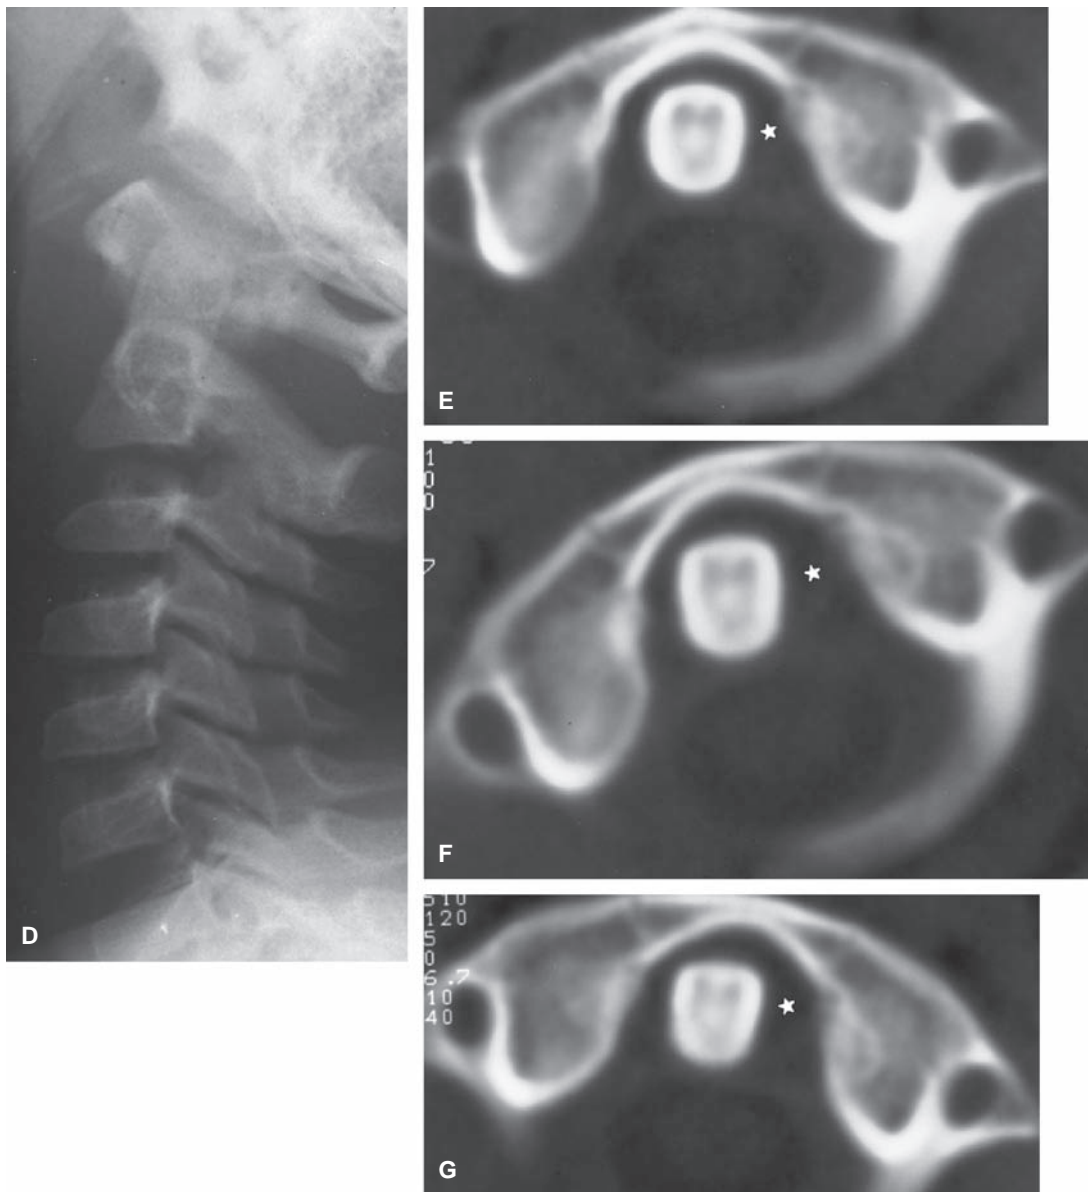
(Continued) D–G: CT evidence of fixed rotary subluxation in a 6-year-old child. D: Lateral radiograph demonstrating mild increased distance of prevertebral space. E: Axial CT scan demonstrating increased distance between dens and patient’s left side of C1 (asymmetry between right and left sides). F: Axial CT scan with patient’s head turned to the right, demonstrating asymmetry between the dens and ring of C1. G: Axial CT scan with patient’s head turned to the left, demonstrating fixed asymmetry between the dens and the ring of C1.
